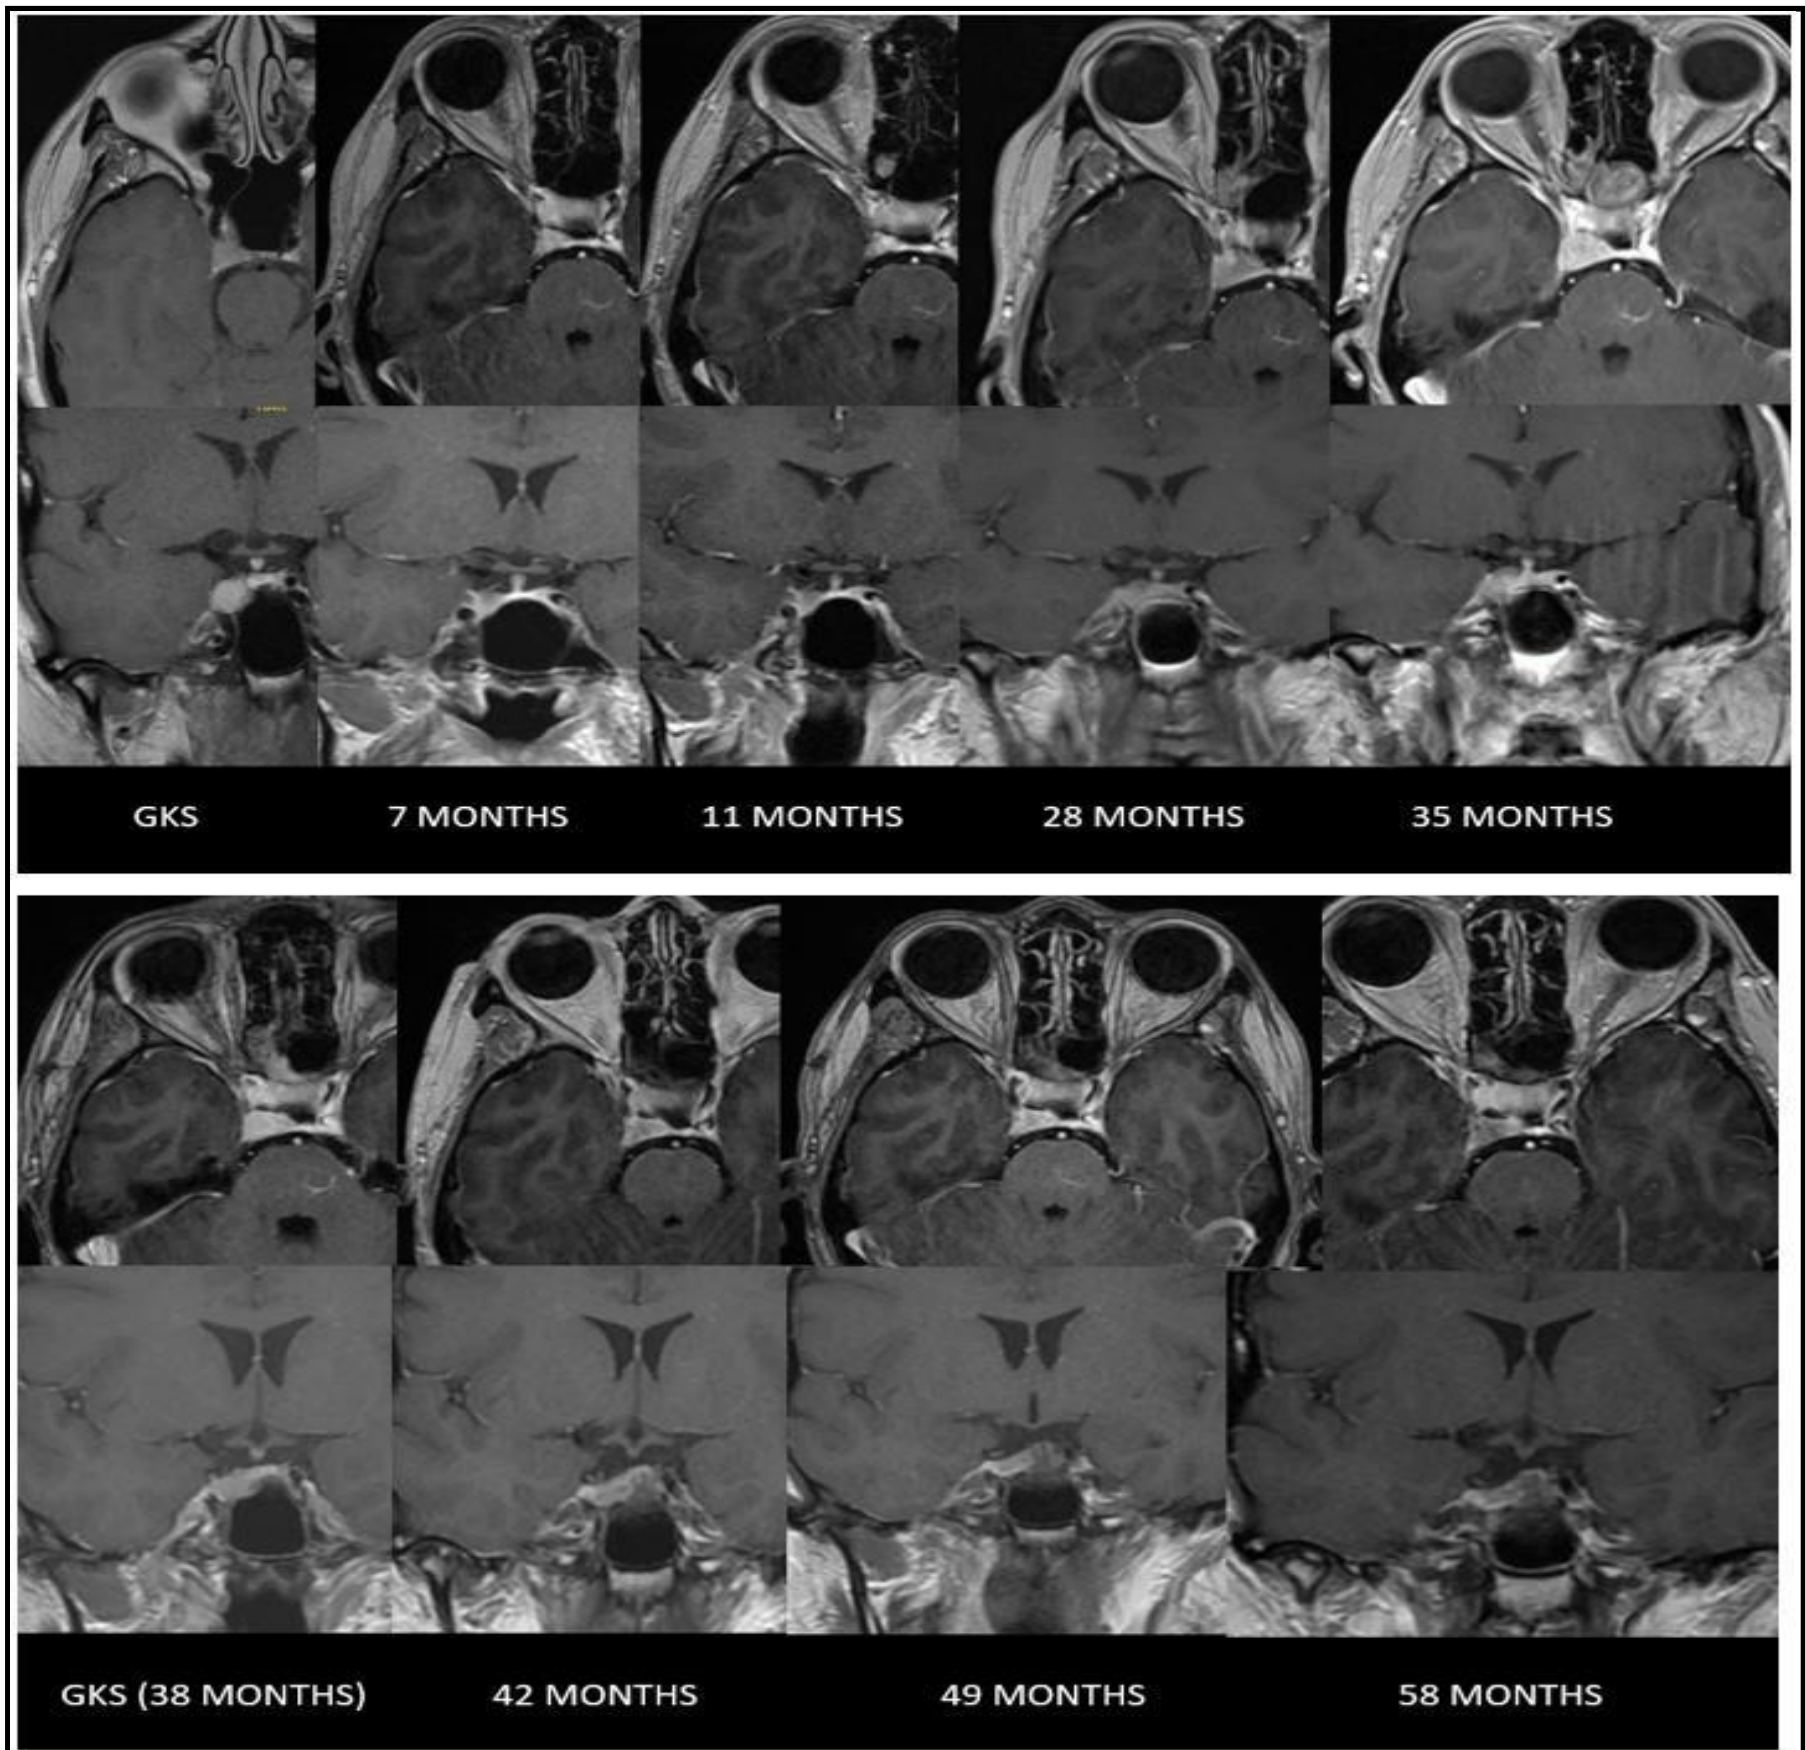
MRI Brain (T1 weighted with contrast) images showing the sizes of the right cavernous sinus lesion on follow-up serial imaging.
